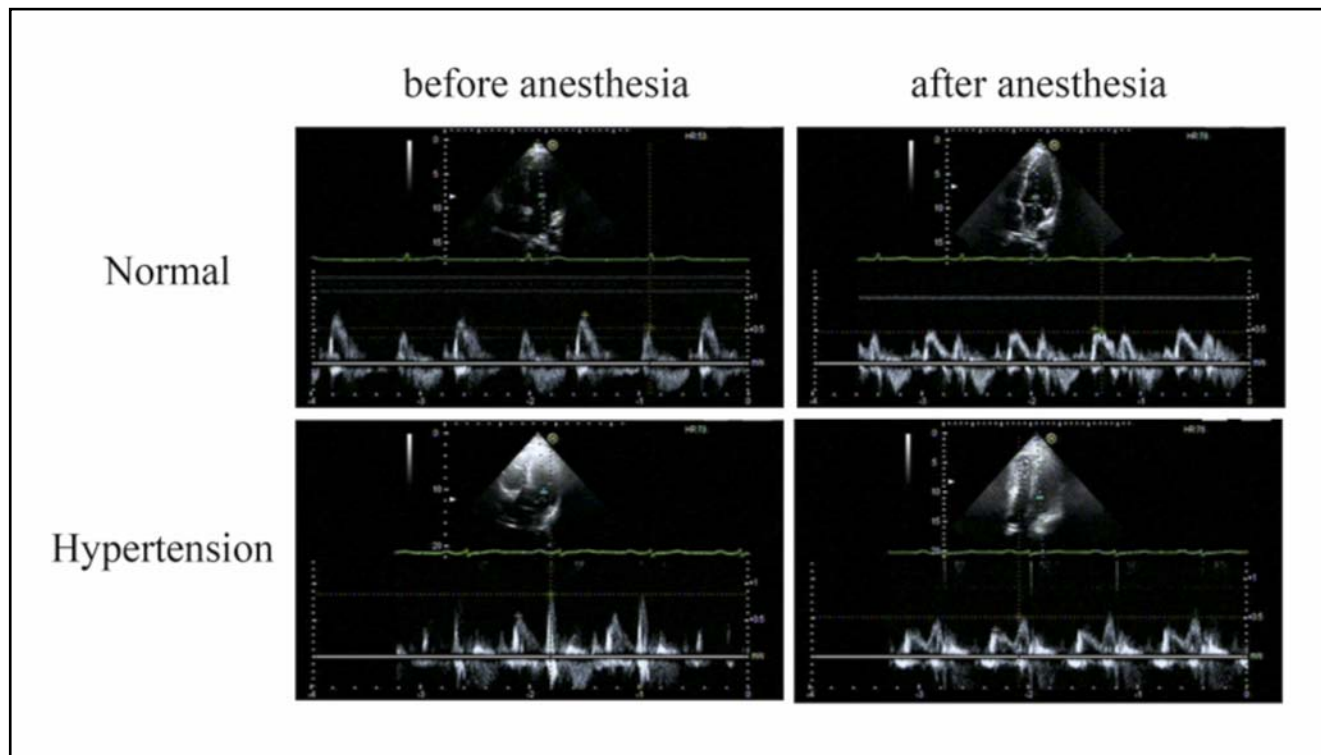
Mitral valve mouth blood flow Doppler before and after General anesthesia in two groups. In hypertension group, E/A is lower than 1 (E/A <1). In both group, E peak all decreased after General anesthesia. While A peak reduced after General anesthesia in hypertension group.
